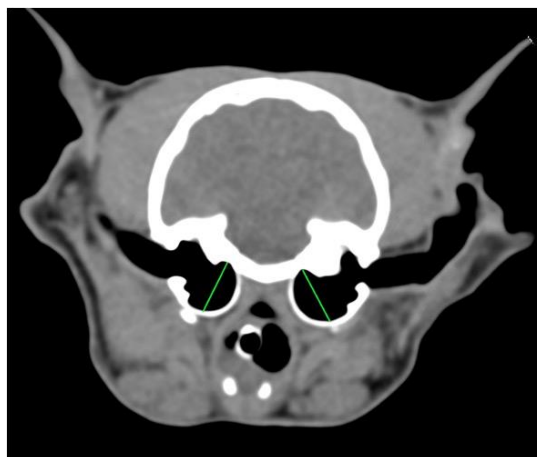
A CT image depicts tympanic bulla height measurement (green line) in the transverse plane.
